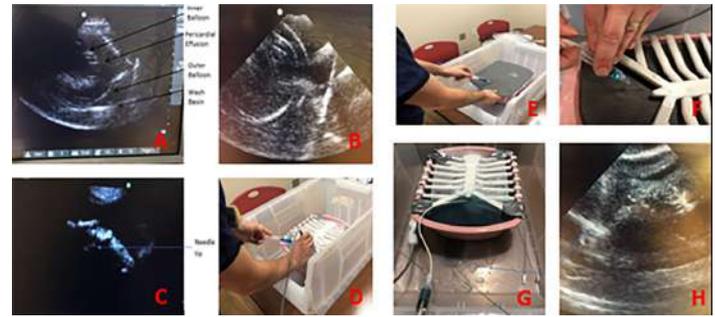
(A-D) Ultrasound-guided approach. (E-F) Blind approach. (G-H) Cannulation with pericardiocentesis kit.
